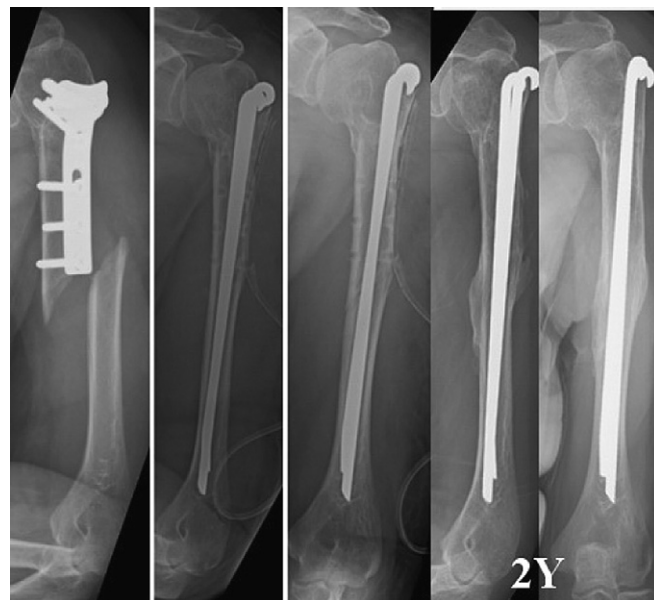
Radiographs of a 66-year-old, 154-cm-tall woman who suffered an AO type A2 humeral shaft fracture secondary to a slip accident. Operation was done by removal of original plate and intramedullary fixation using two 20-cm Rush pins. Last radiographs were taken 2 years after operation, and bony union was noted. Patient regained satisfactory function of the upper limb.
